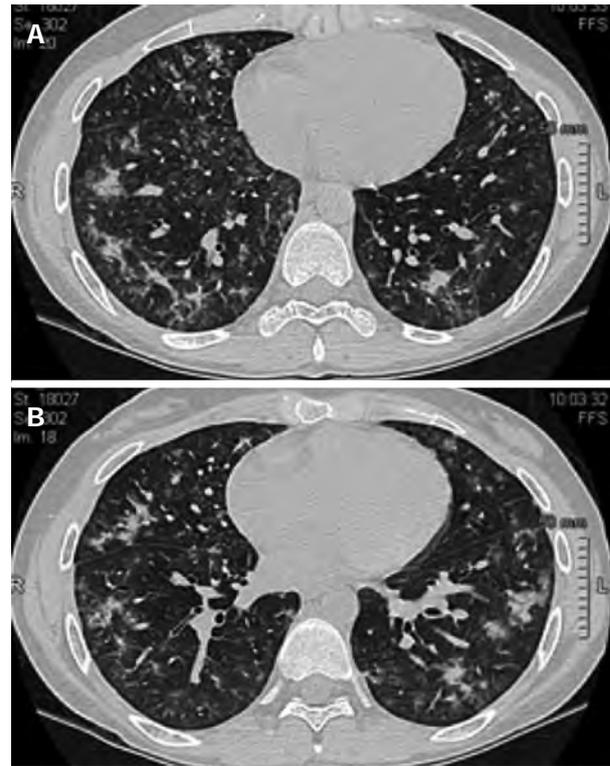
High-resolution computed tomography at hospital admission in the Pneumology Unit. High-resolution computed tomography of the thorax revealed bilateral shadowing nodules and adjacent interstitial (A) thickening with a predominant distribution in the middle and basal regions and relative sparing of the apices (B). R: Right; L: Left.
